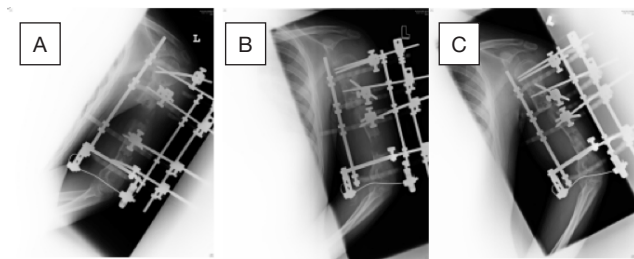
plain radiographs of left humerus at (A) 0 month, (B) 3 months and (C) 6 months follow up; showing radiological evidence of good callus formation and consolidation over callotaxis site
